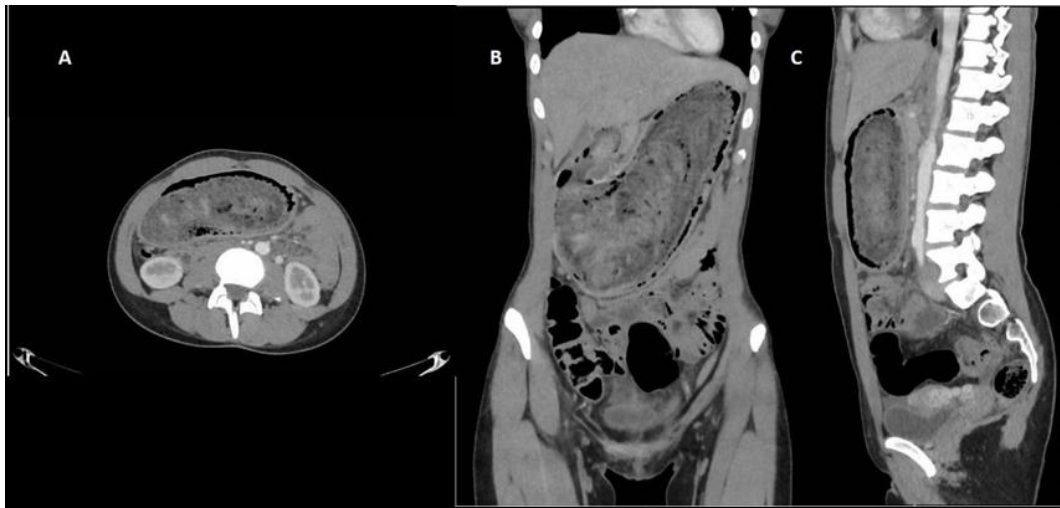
CT scan Giant gastric trichobezoar. (A) Coronal image. (B) Axial image. (C) Sagittal image.
